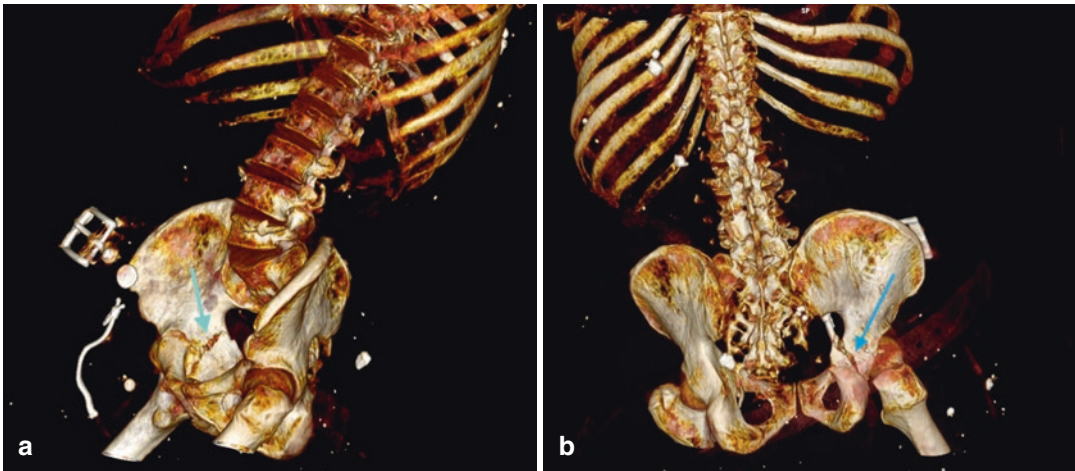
Unenhanced CT of a young man ran over from a vehicle. The volume rendering reconstruction image highlights a length and direction of the iliac bone and of the sacro-iliac junction (a right; b left)
